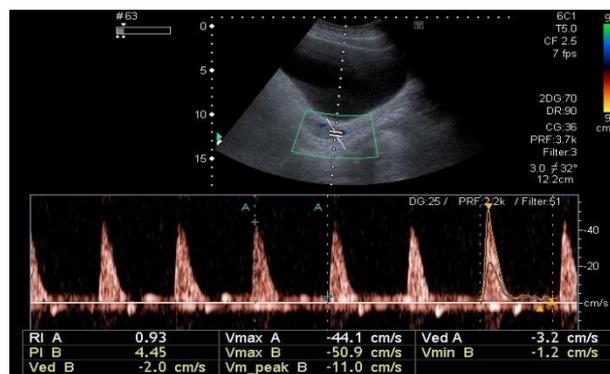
(b): Doppler ultrasound of right uterine artery shows pulsatility index and Resistive index
